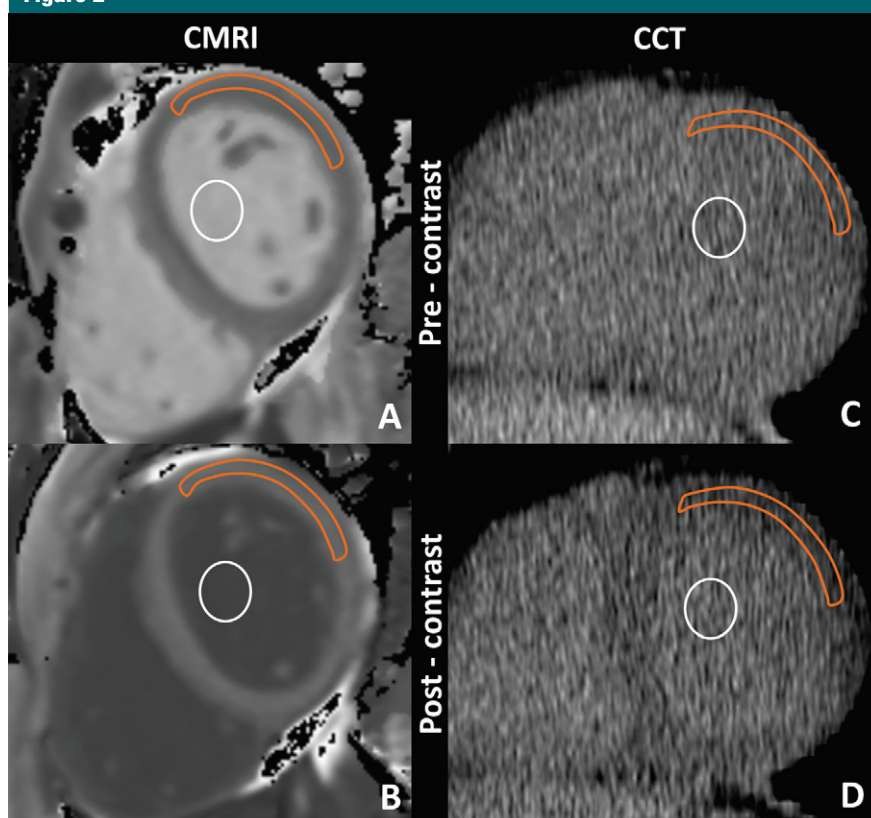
Cardiac MR imaging region of interest measurements obtained, *A*, before and, *B*, after gadolinium chelate administration and reformatted cardiac CT region of interest measurements obtained, *C*, before and, *D*, after administration of an iodinated contrast agent. For cardiac CT, the anterolateral myocardium was most reliably identified before administration of an iodinated contrast agent. There, a region of interest from the anterolateral myocardium was used for attenuation measurements. A focal myocardial scar was identified on delayed cardiac MR images and was not included in the region of interest. Orange outline = myocardium, white circle = blood pool.
